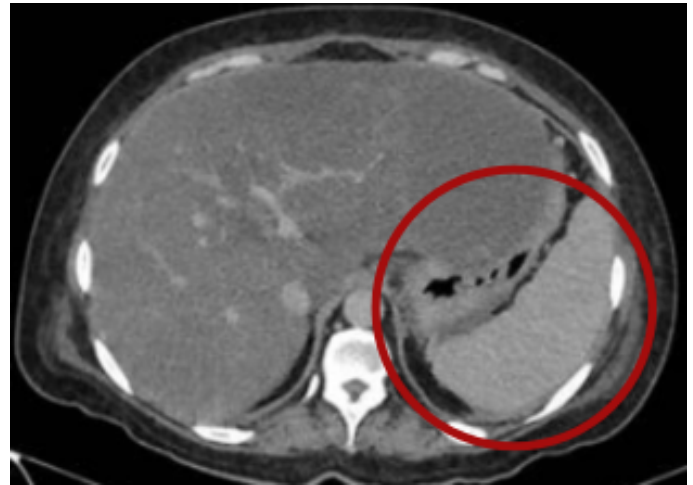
Portal venous phase contrast-enhanced abdominal CT showing a peripancreatic collection with homogeneous hypodense content and a thin, well-defined wall, causing displacement of the lesser gastric curvature.
